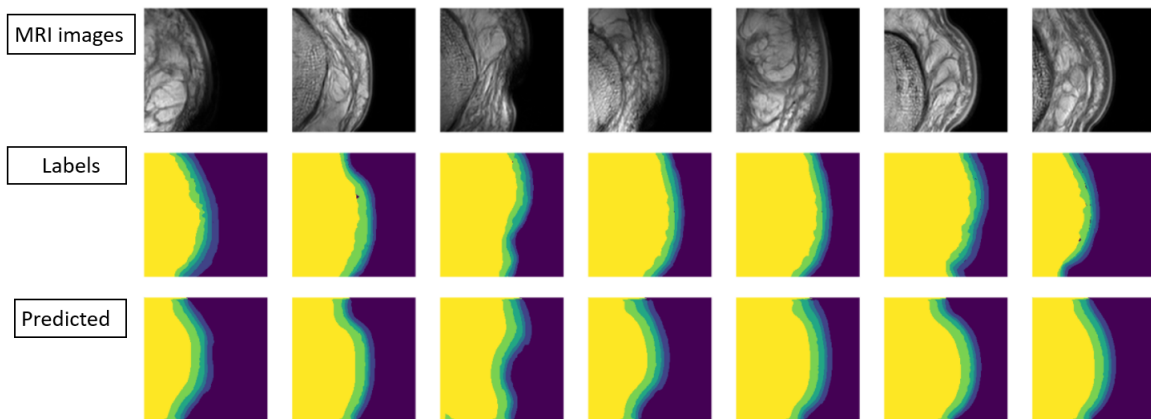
through MRI images, manual labels, and predicted of MRI images using U-net.
